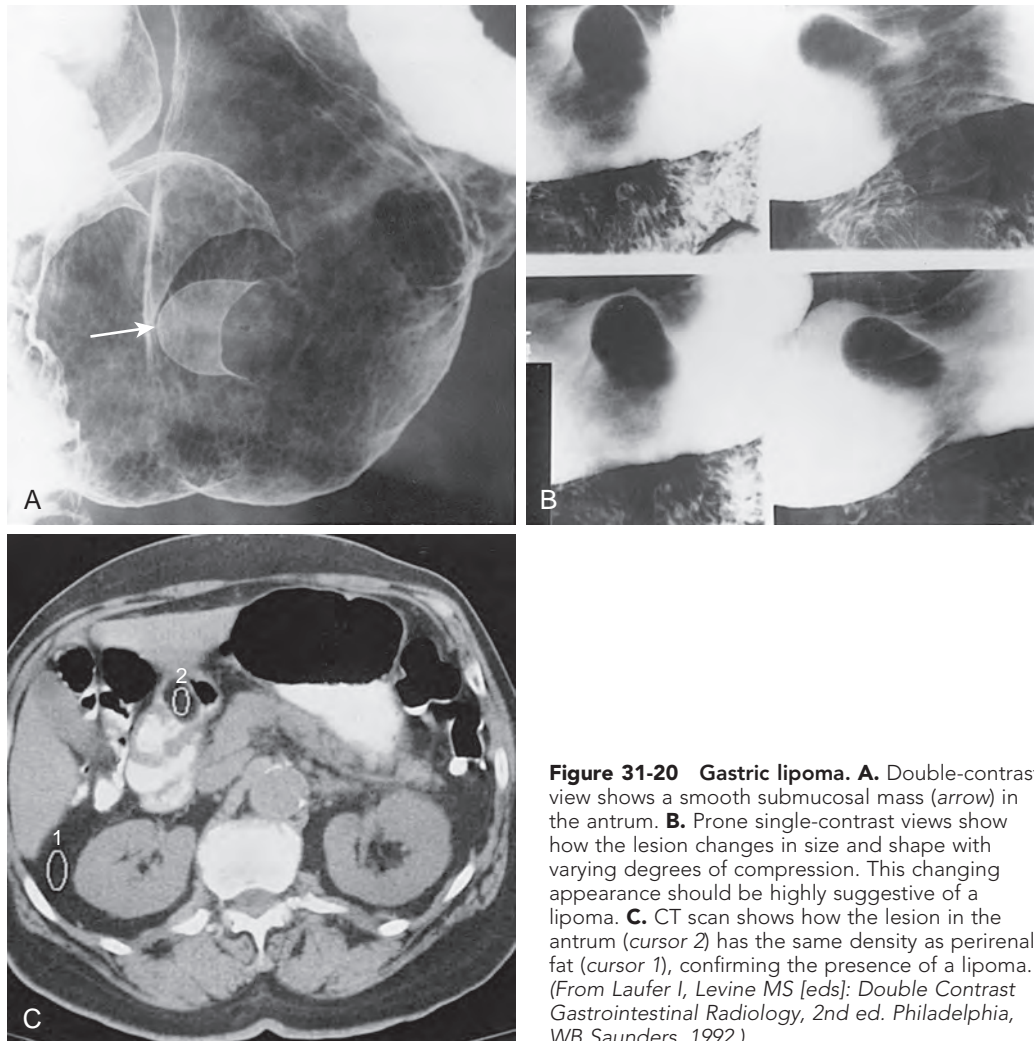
Gastric lipoma. A. Double-contrast view shows a smooth submucosal mass (arrow) in the antrum. B. Prone single-contrast views show how the lesion changes in size and shape with varying degrees of compression. This changing appearance should be highly suggestive of a lipoma. C. CT scan shows how the lesion in the antrum (cursor 2) has the same density as perirenal fat (cursor 1), confirming the presence of a lipoma. (From Laufer I, Levine MS [eds]: *Double Contrast Gastrointestinal Radiology*, 2nd ed. Philadelphia, WB Saunders, 1992.)
